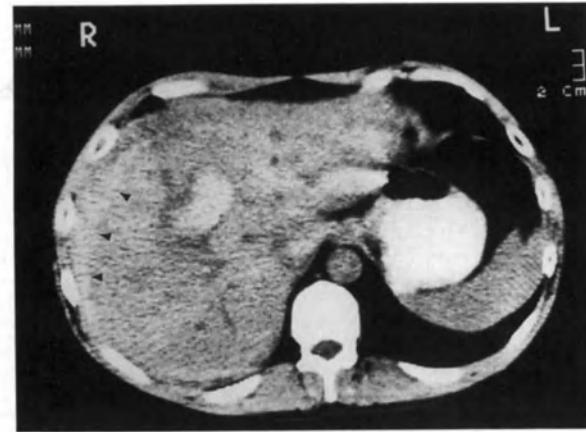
CT scan unenhanced. High density intrahepatic hematoma and subcapsular hematoma (arrows). Recent stab wound: same patient as Fig. 26.31.
